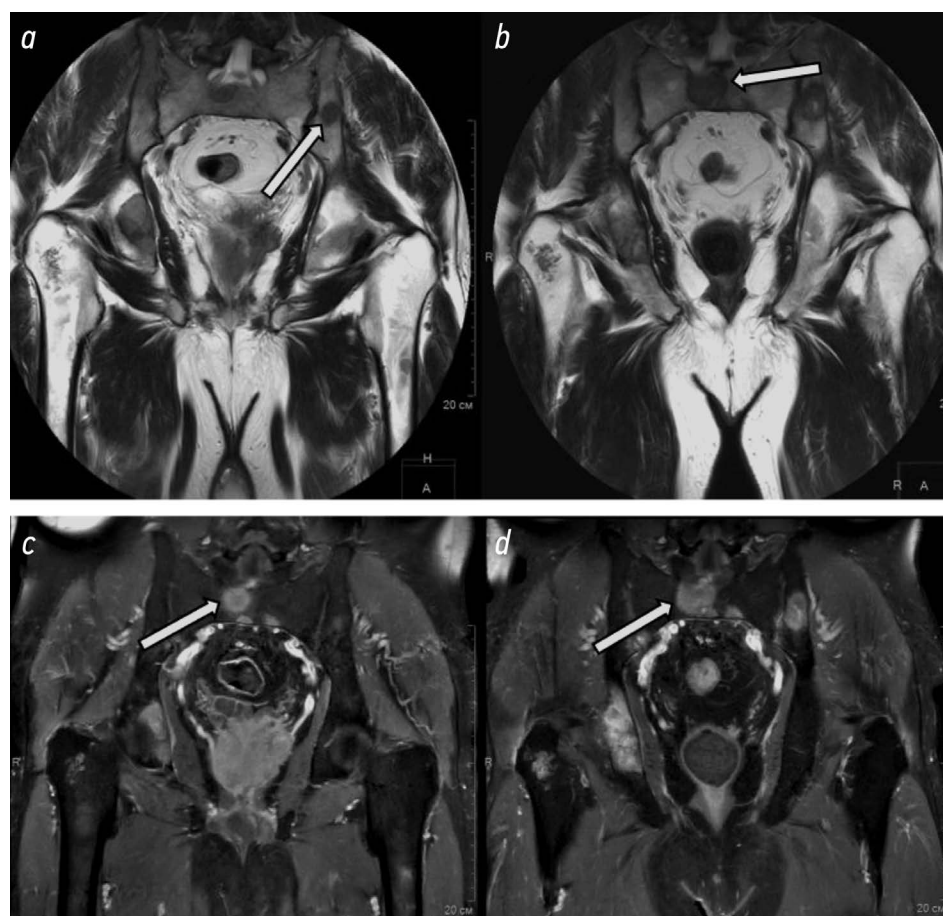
a, b*, Pelvic MRI, coronal plane, T2WI; *c, d*, pelvic MRI, coronal plane, T1WI; case follow-up *a, c* of February 2023 and *b, d* July 2023: osteoblastic lesions in pelvic bones, increase in lesion size during follow-up (white arrows).
